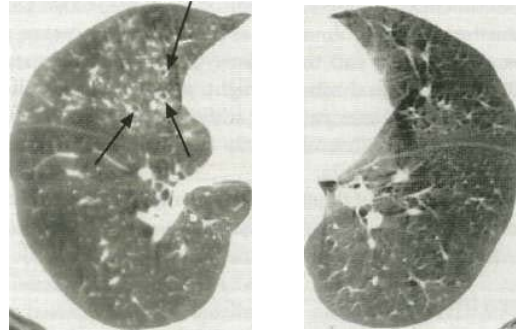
CT scan showing bronchiectasis in the right middle lobe. Note dilated bronchi with thickened wall and adjacent artery giving a signet ring appearance.
